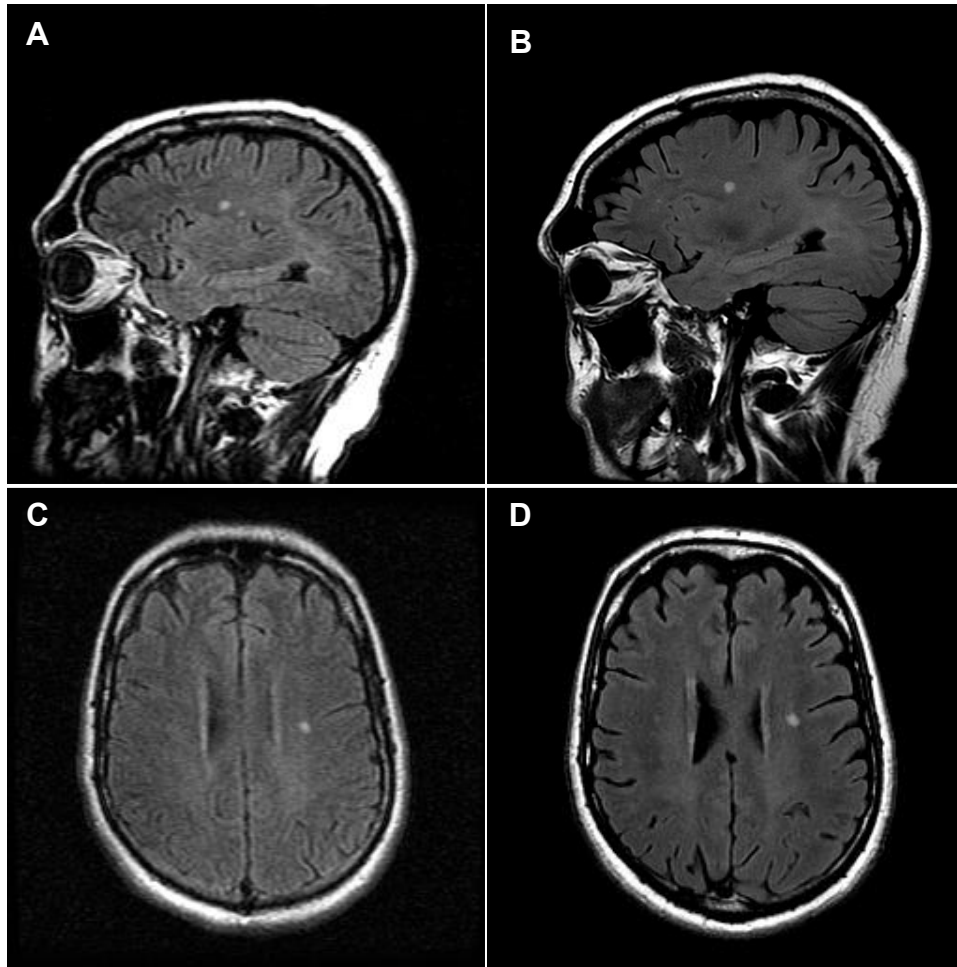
Sagittal and axial FLAIR images from the same patient one year apart. Images A and C were scanned on a 1.5T single-channel head coil. Images B and D were scanned on an 8-channel phased array head coil on a 3.0T system. Overall signal-to-noise ratio and visual sensitivity is greater on Images B and D, demonstrating technical advantages of phased array coils and higher field strength imaging.
